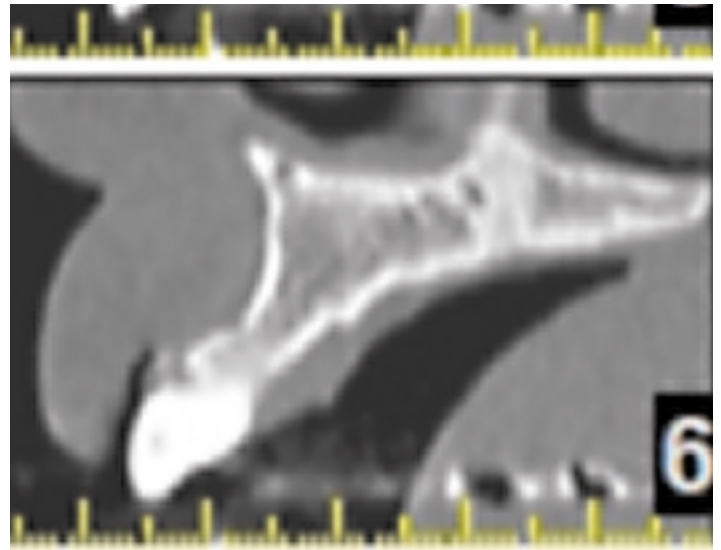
Fortunately, a CBCT scan was done prior to treatment planning which ensured a proper diagnosis and plan for ridge augmentation for future implant placement.
